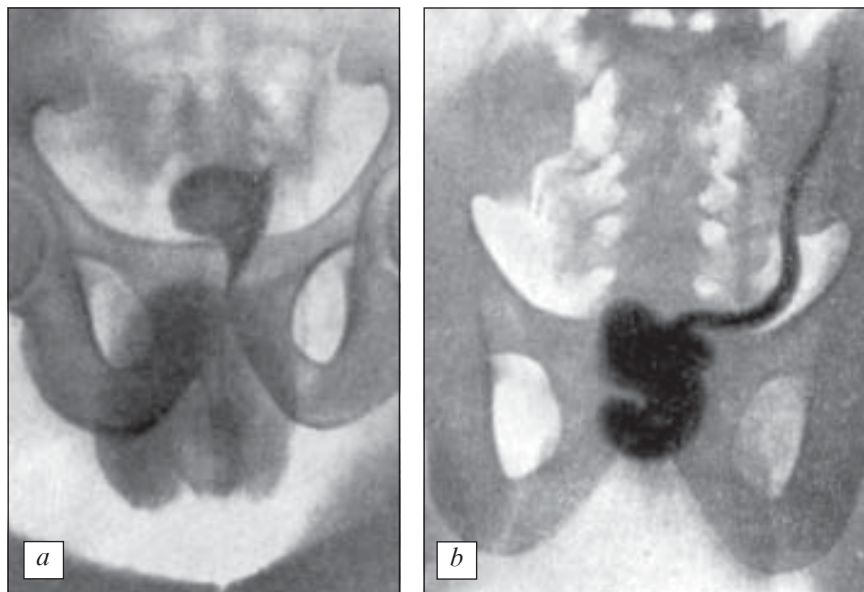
X-ray-urologic examination of patients with tuberculosis of the urinary system: *a* — a contracted urinary bladder; *b* — a contracted urinary bladder, vesicoureteral reflux, a cavern of the prostate is overlapped to a shadow of the contracted urinary bladder
